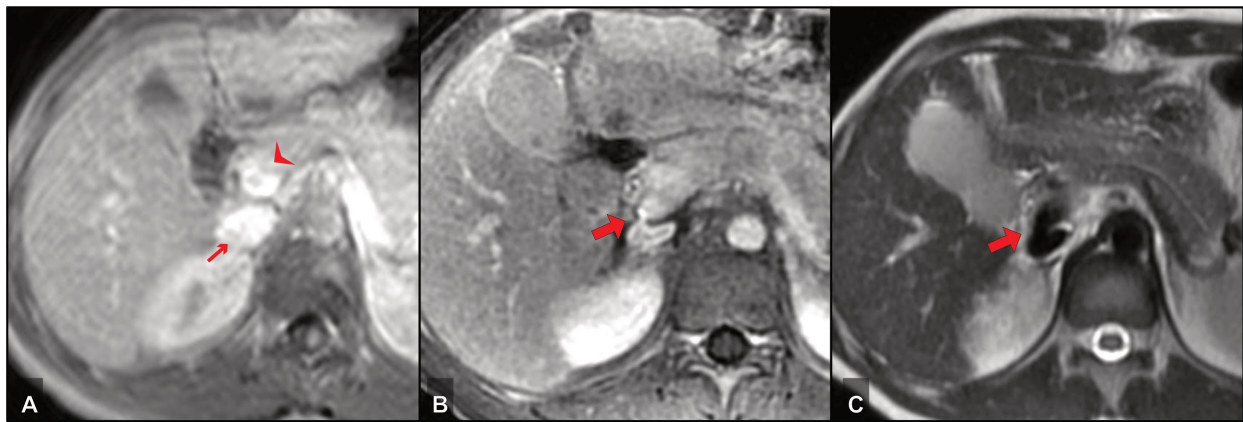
17-year-old female patient with Wilson's Syndrome and recurrent variceal bleedings – PSS procedure: portacaval side-to-side; A: Preoperative MRI, post-contrast T1-w; B: Postoperative MRI, post-contrast T1-w; C: Postoperative MRI, T2w; Small arrow: IVC, Arrowhead: Portal vein, Bold arrow: Portacaval anastomosis. (Reprinted with permission from Fehrenbach U, Gül-Klein S, de Sousa Mendes M, *et al.* Portosystemic shunt surgery in the era of TIPS: imaging-based planning of the surgical approach. *Abdom. Radiol.* (2020))
